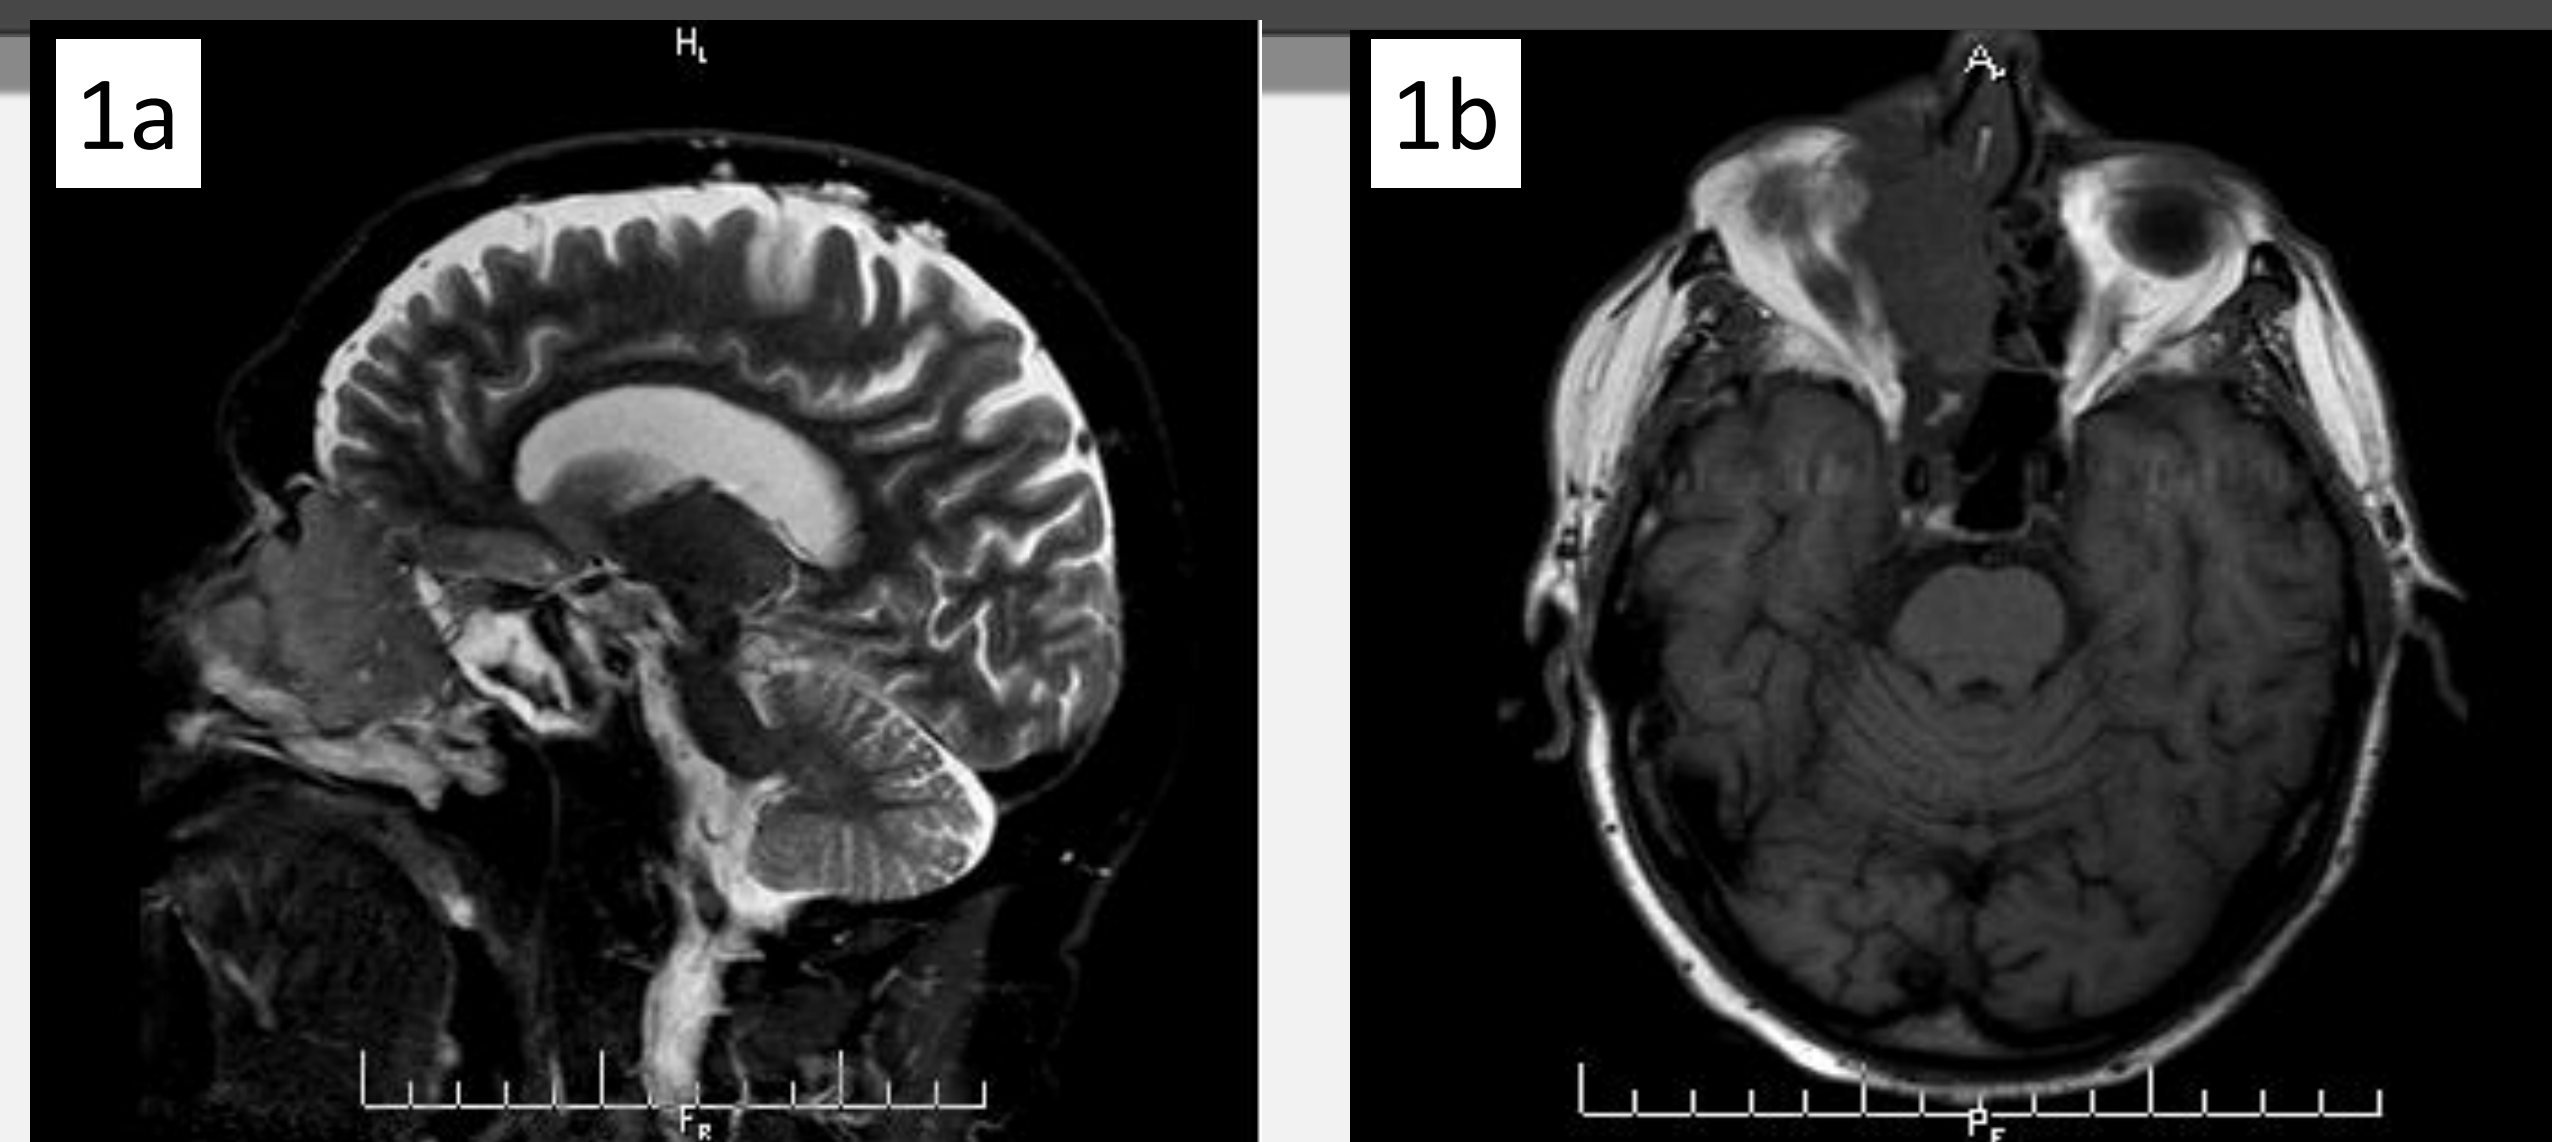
MRI of Brain/Orbits without contrast shows a lobulated mass in the right maxillary and ethmoidal sinuses with invasion into the right orbit with compression of the inferior medial rectus muscle (sagittal and axial views)
